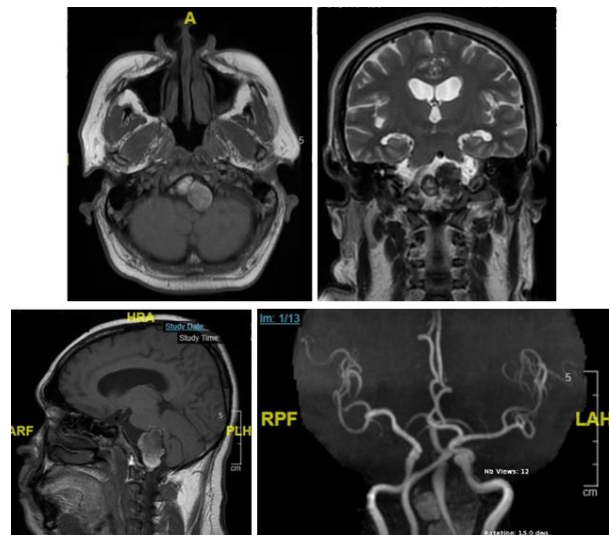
Post-TFCA MRI-MRA showing stable left V4 aneurysm without steno-occlusion.
